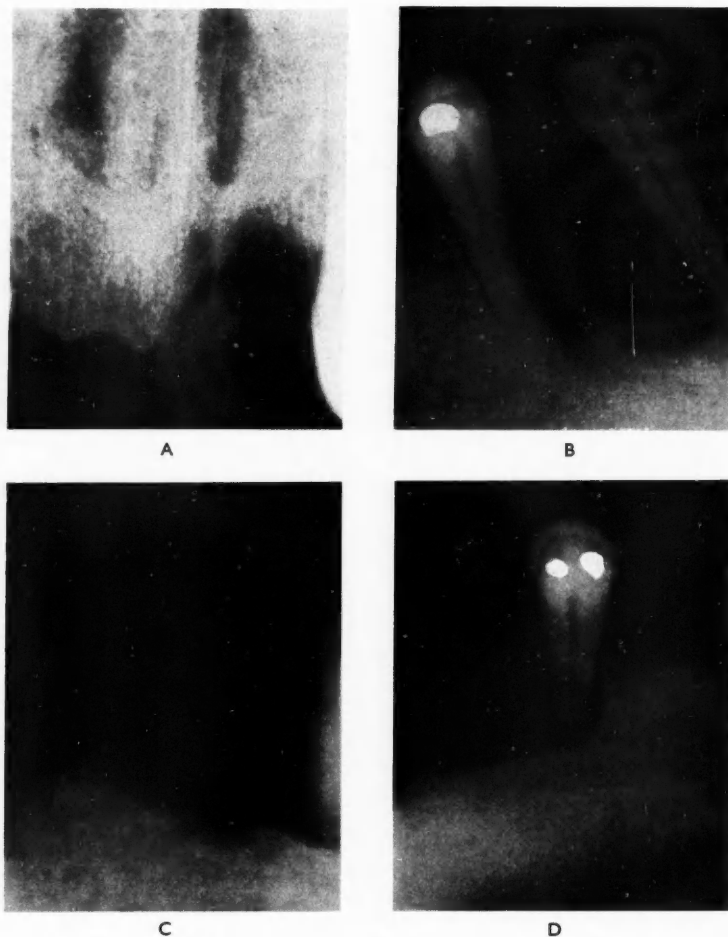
Radiographic examination showing: A, Incomplete healing of upper left lateral socket. B, C, D, Gross loss of mandibular alveolar bone anterior to the pre-molars.
